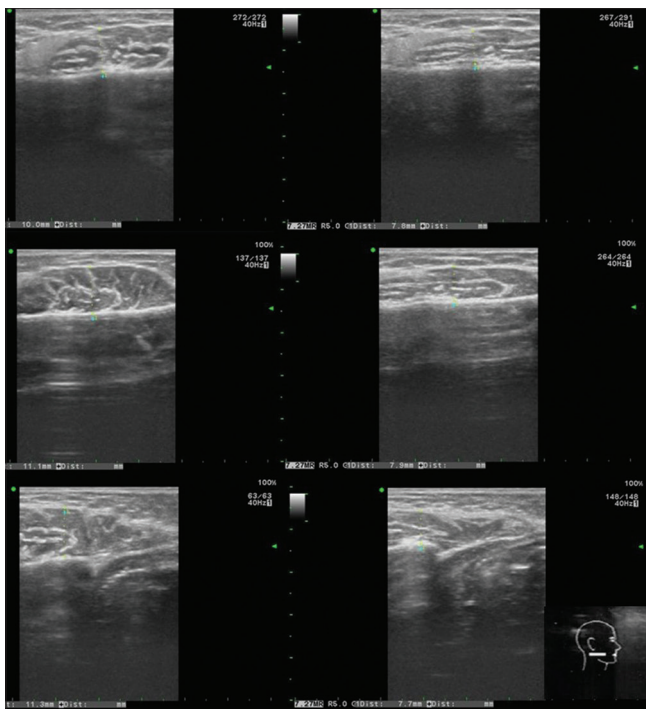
USG image of the right masseter muscle at RST and MVC. USG: Ultrasound, MVC: Maximum voluntary contraction, RST: Rest
